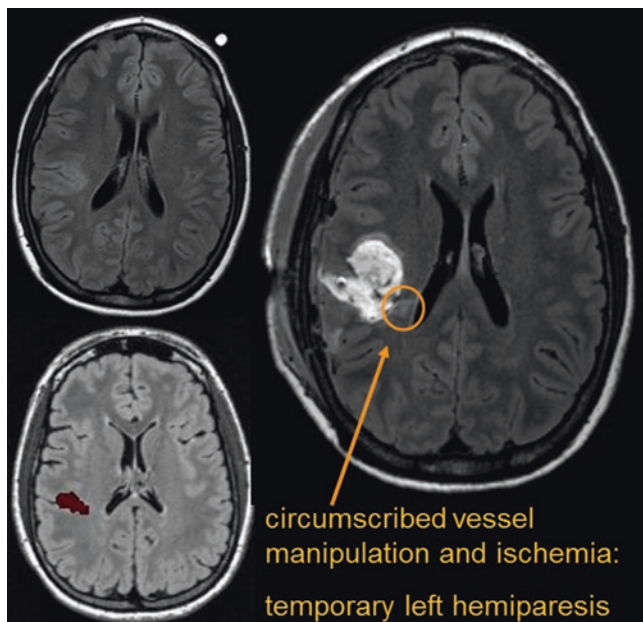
Complication: ischemia after extended lesionectomy. Preoperative axial FLAIR image (*upper left*) and preoperative MRI with segmented object (*dark red area*) indicating an epileptogenic lesion (*lower left*). The postoperative image on the right shows the resection cavity after an extended right lesionectomy as planned but also a circumscribed ischemia (*circle*) medially adjacent to the resection cavity, probably caused by small vessel manipulation or coagulation. The patient suffered a temporary left hemiparesis (leg > arm), but recovered completely after a few weeks
